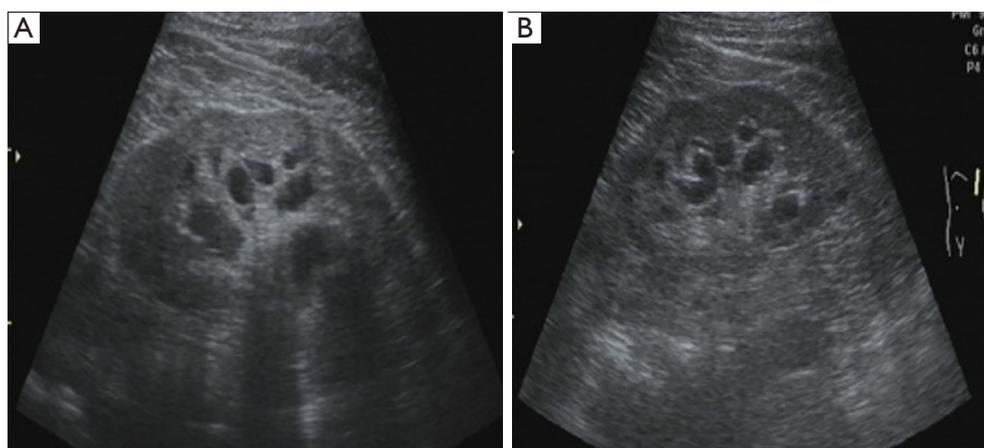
A male (patient C) with known renal lymphangioma (case 3). (A) Ultrasonographic findings of the right kidney. (B) Ultrasonographic findings of the left kidney.
